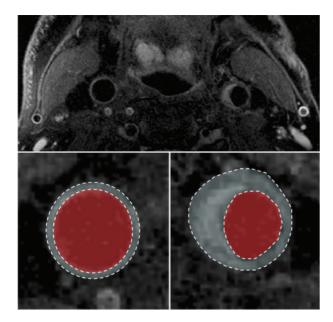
High-resolution T2-weighted transverse MRI of the neck. The upper panel shows a normal smooth-walled right carotid artery. By contrast, the left carotid contains a large heterogeneous eccentric atherosclerotic plaque. The lower panel shows the method for quantifying vessel wall area (shaded). Serial quantification of anatomically aligned slices can be used for studies of atherosclerosis progression and regression
